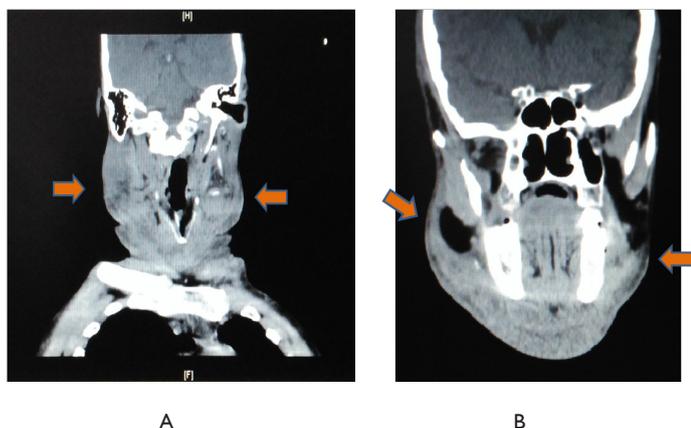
CT Skull, Neck & Upper Chest.
